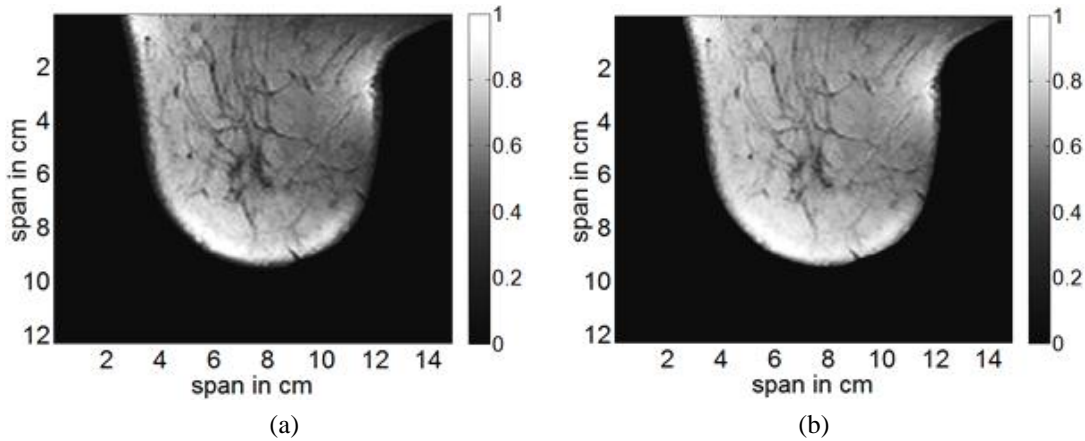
Application of homomorphic filtering on an MRI slice corrupted by a bias field.
